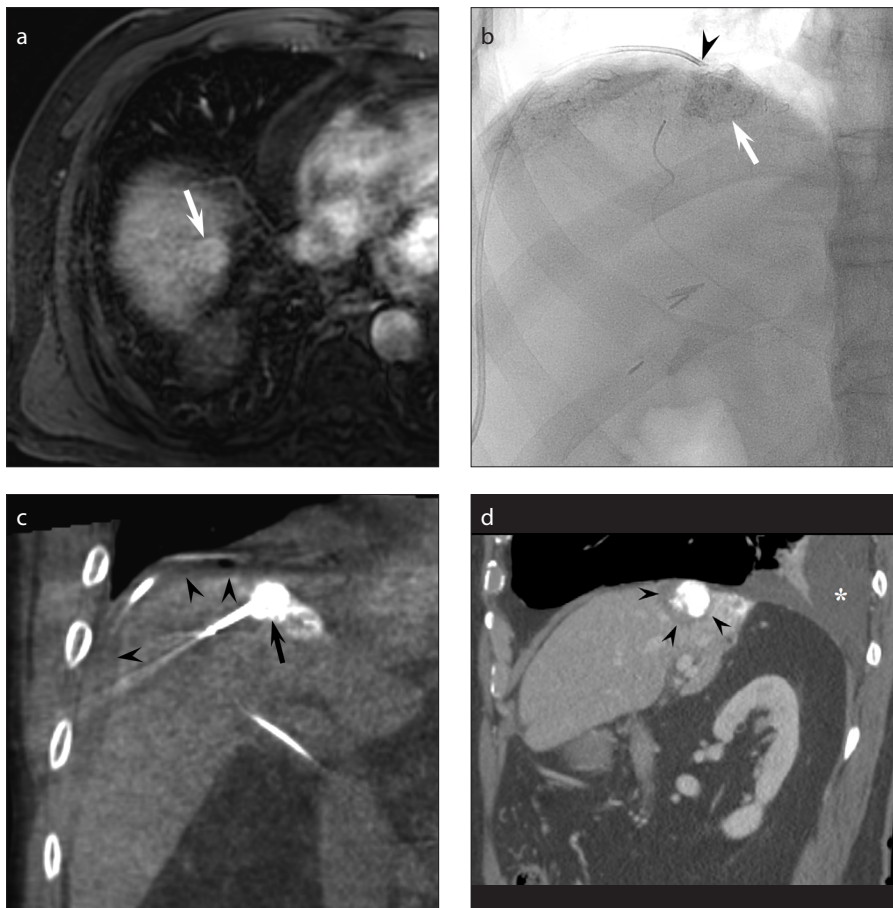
a–d. RFA with GIH for subcapsular HCC in a 66-year-old man with failed artificial ascites due to perihepatic adhesion (case No. 5). Arterial phase axial magnetic resonance image (a) demonstrates a 2.2 cm diameter HCC in hepatic segment VIII (arrow), abutting the diaphragm. Spot image obtained during creation of GIH after TACE (b) shows the catheter tip (arrowhead) in the perihepatic space near the tumor with iodized oil retention (arrow). Coronal CBCT image (c) obtained before ablation confirms the final position of RFA electrode tip in the tumor (arrow). The fluid introduced for GIH (arrowheads) is also seen. Portal phase sagittal CT image obtained 1 day after RFA with GIH (d) demonstrates an ablation zone surrounding the tumor (arrowheads) and no thermal injury to the adjacent diaphragm. Right pleural effusion (asterisk) may represent transdiaphragmatic shifting of the fluid introduced for GIH.
